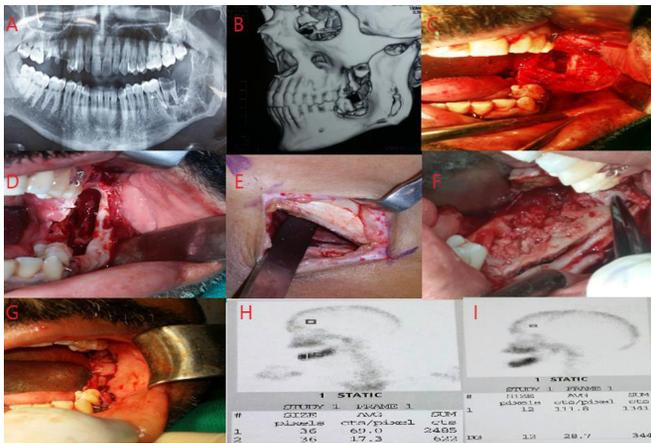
A,Odontogenic Myxoma on the left side mandibular angle area, B, CT scan showing bony distruction, C, Pathology removed, D, Host bed preparation ,E, Graft harvest from the illiac, F,Defect area filling with Autogenous iliac bone,G, Surgical site sutured, H and I, Show Scinitigraphic results at 1 month and 3 month
